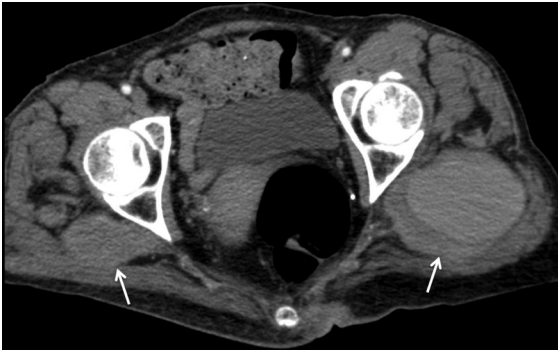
CT imaging of bilateral PSAAs, arrows demonstrating aneurysms. Note asymmetric contrast as right side is occluded.
